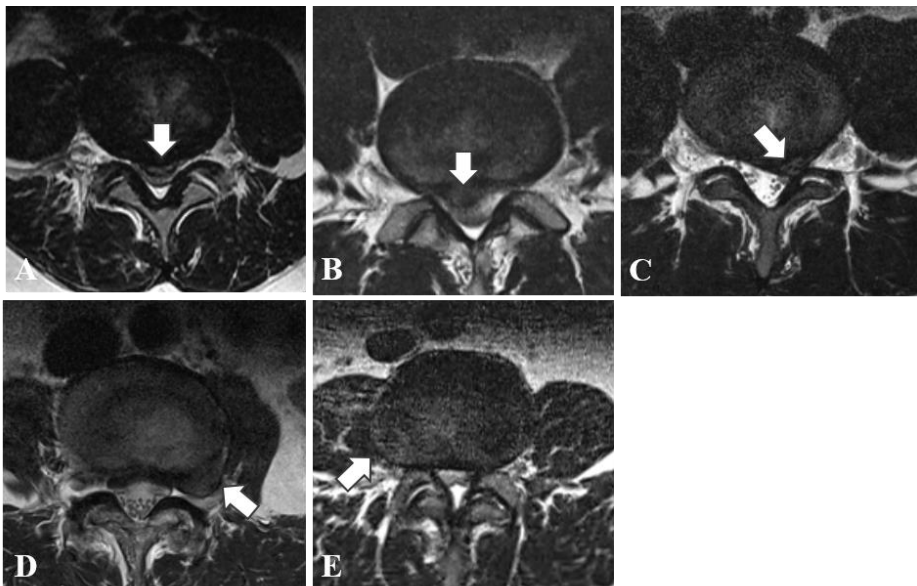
Axial MR images showing the location of HIVDs in the horizontal plane: A disc herniation (arrows) in the central (A), paracentral (B), subarticular (C), foraminal (D), and extraforaminal (E) zone.
